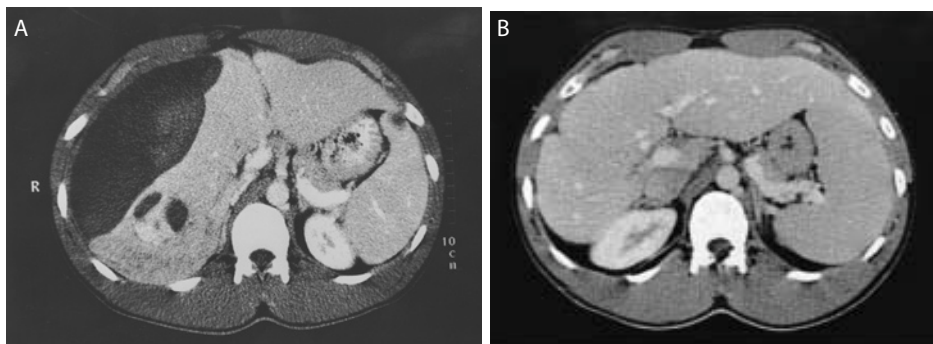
a. Computed tomogram at presentation showing a ruptured hepatocellular adenoma (asterisk) with subcapsular haematoma. The haematoma has displaced the right kidney (not seen in this figure) caudally and the falciform ligament (arrows) to the left. b. Computed tomogram at 15 months' follow-up of the same patient, treated conservatively. No adenoma was detectable and total regression of the subcapsular haematoma was noted. The right kidney and falciform ligament have been replaced.
